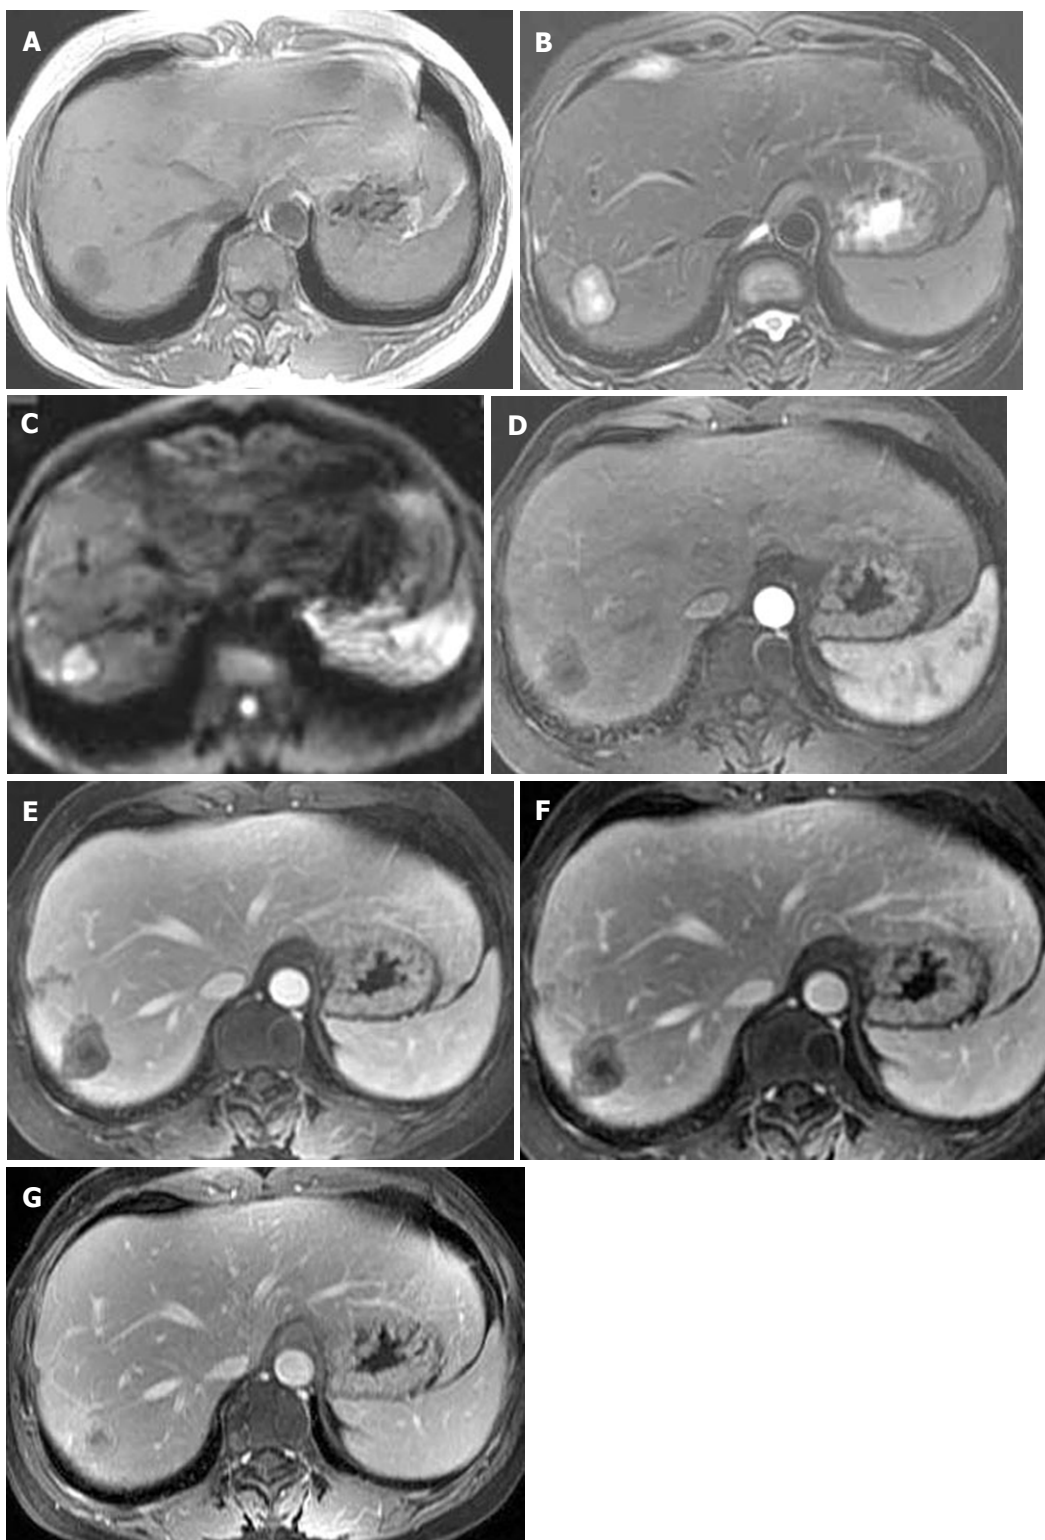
Multifocal hepatic epithelioid hemangioendothelioma in a 48-year-old female. Precontrast axial magnetic resonance imaging scan of the liver shows multiple lesions of low signal intensity with peripheral faint hyperintensity on T1WI (A), high signal intensity with peripheral hypointensity and an area of evident hyperintensity in the center of one lesion on T2WI (B), and hyperintensity with peripheral hypointensity on diffusion weighted imaging (C). Lesions show peripheral ring-like enhancement in the arterial phase (D), and heterogeneously progressive reinforcement in the portal venous phase (E), equilibrium phase (F) and it approaches isointensity to liver parenchyma in the delayed phase (G). There is an association with an area of unenhanced necrosis in the center, which looks like a conspicuous "target" with an inner low intensity, in-between high intensity and outer lower intensity layers.
